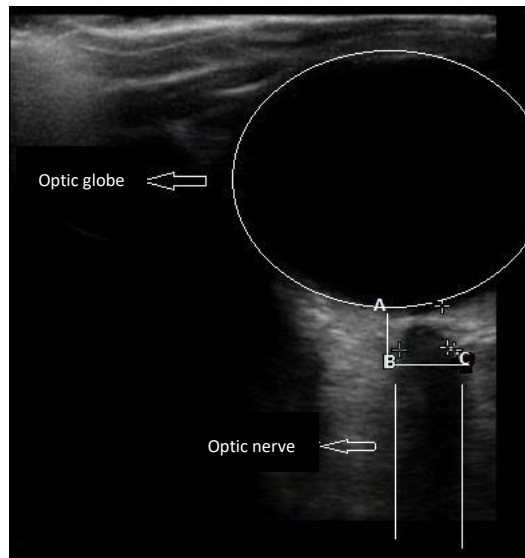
Ultrasonographic image of optic nerve sheath diameter measurement. (A) Optic nerve exit from the eyeball. (B) 3 mm posterior to the exit from the eyeball for OSND measurement. (C) Transverse measurement of OSND.
